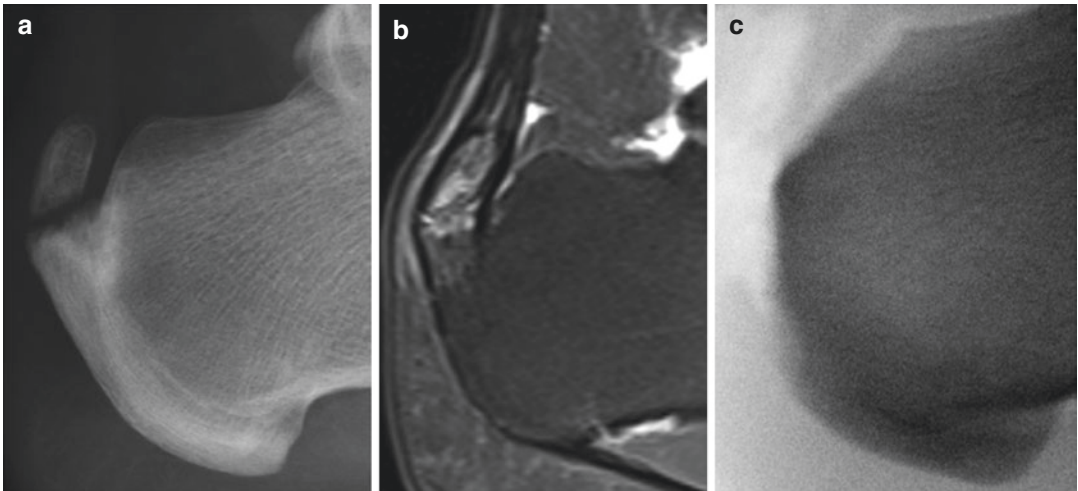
Preoperative insertional Achilles tendonopathy radiograph (a) and MRI (b) with large intratendinous enthesophyte. Intraoperative imaging of Achilles tendon elevation, excision of enthesophyte and reattachment (c)
